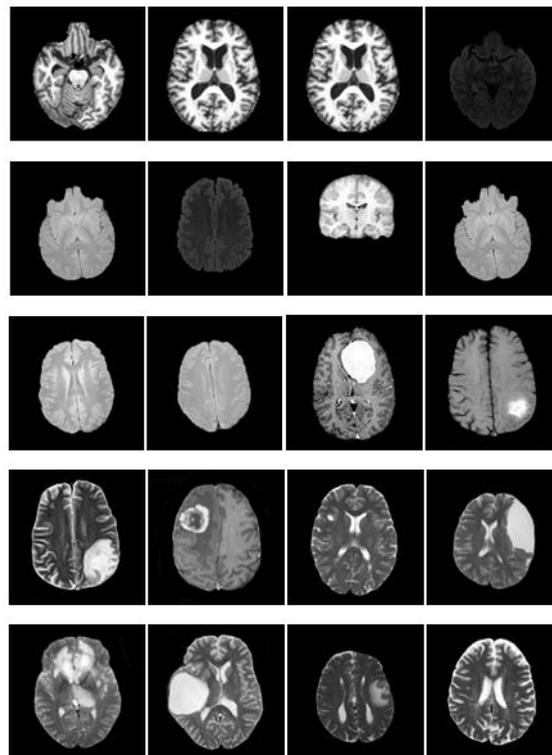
Skull Stripped MRI Normal and Abnormal Brain images
